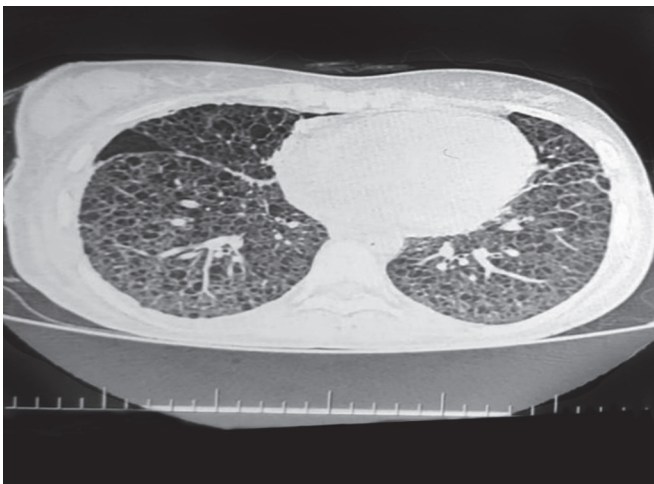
CT chest of the same patient showing expanded lung after tube thoracostomy
